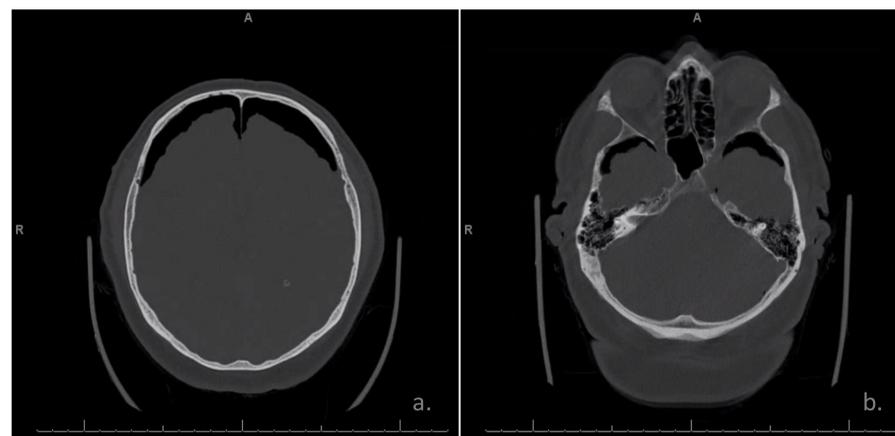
Initial CT Head without contrast demonstrating pneumocephalus most pronounced overlying both frontal cerebral convexities with tenting of the anterior aspects of the frontal lobes. 1b. Initial CT Head without contrast demonstrating pneumocephalus overlying the anterior aspects of both middle cranial fossae.
